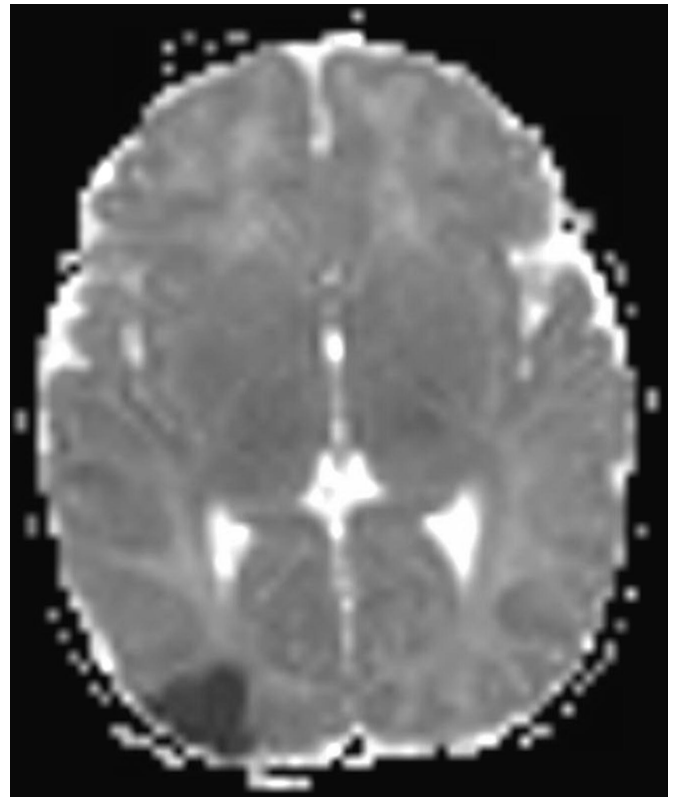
Focal restriction of diffusion on cranial MRI at 24 hours of life, delineating a recent ischaemic lesion in the superficial posterior territory of the right median cerebral artery.
